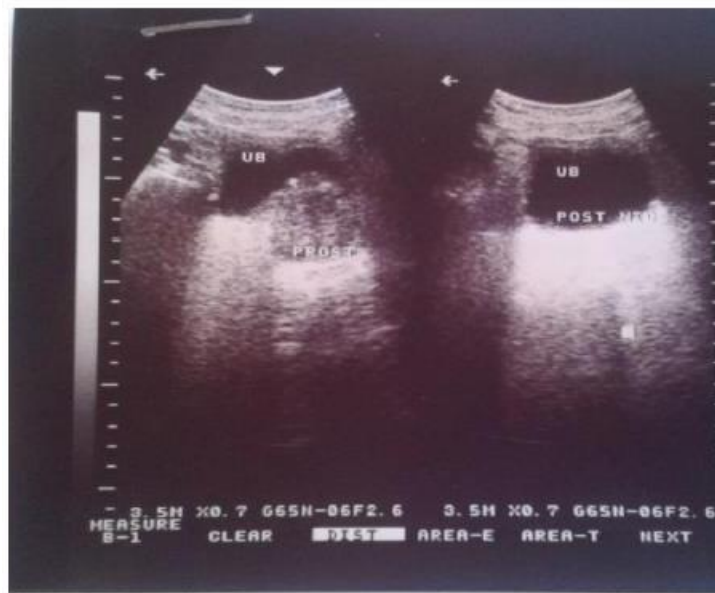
ultrasound image of PBH and post void residual urine in 58 years old man
